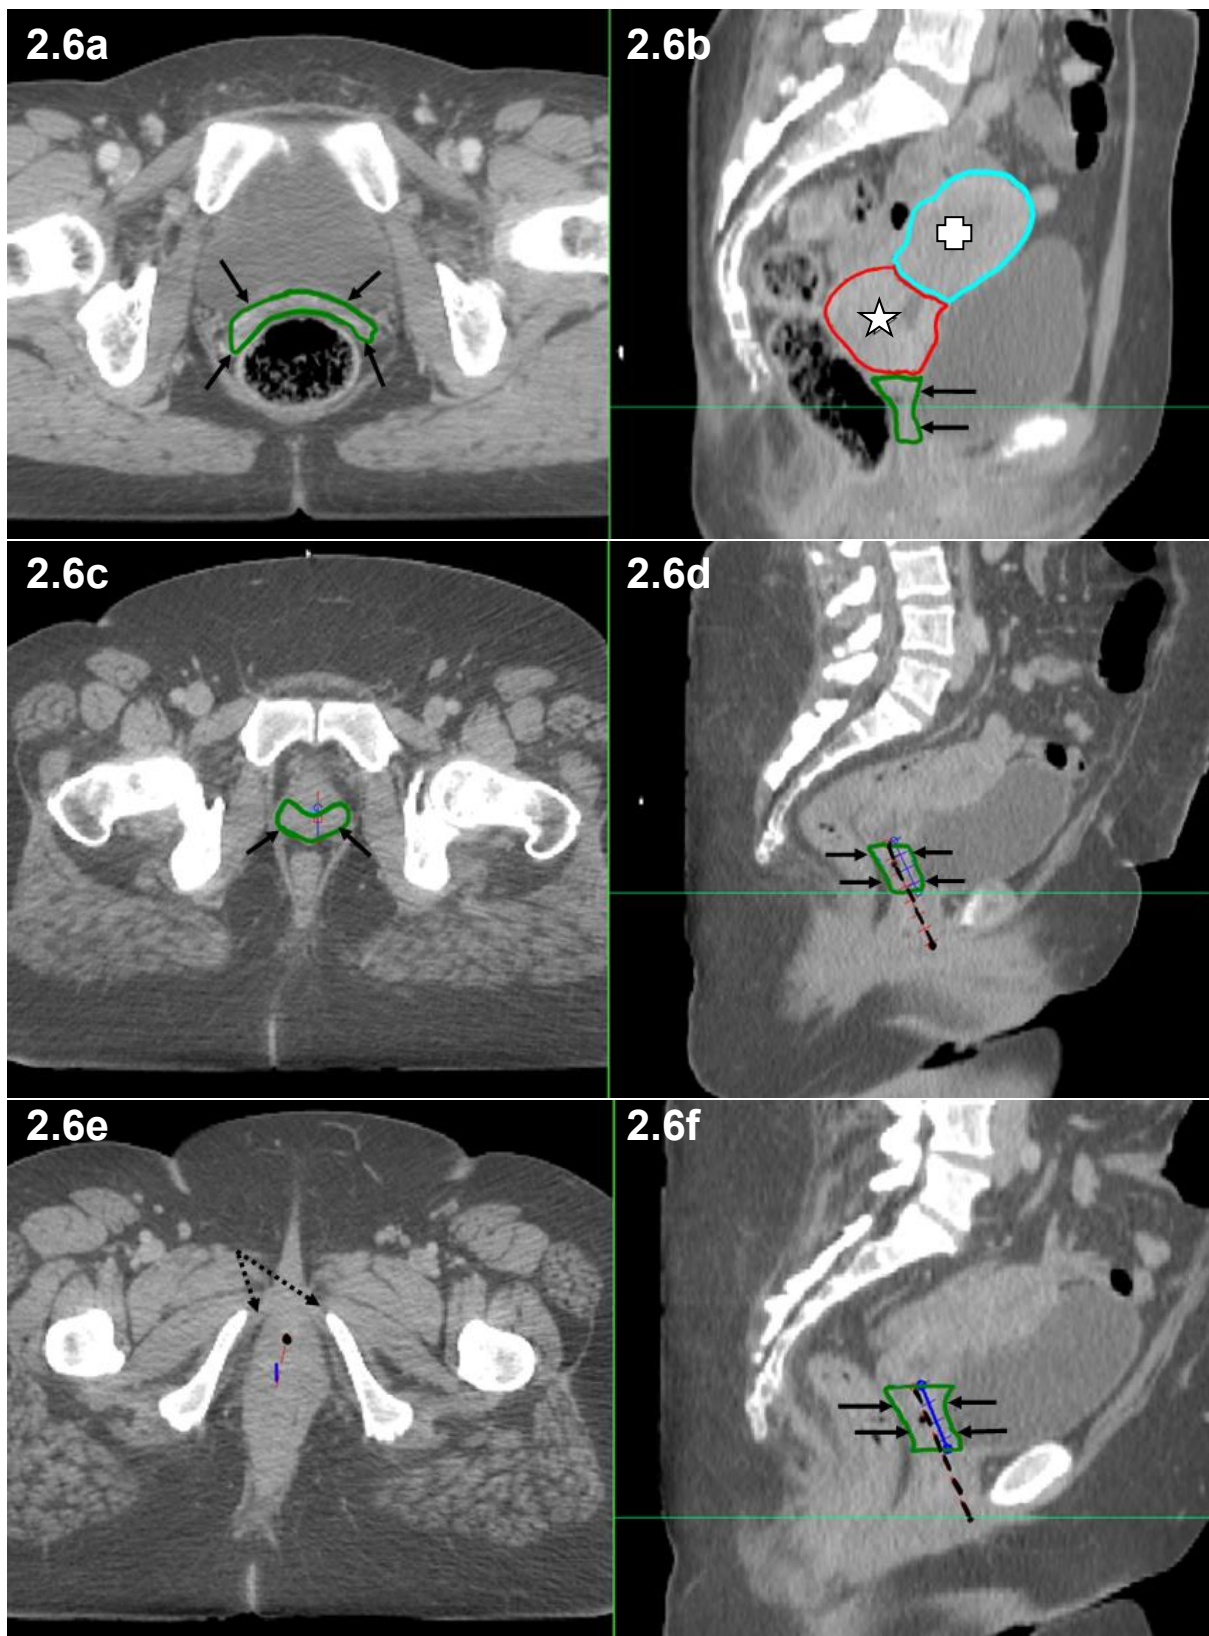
Transverse (a, c, e) and sagittal (b, d, f) CT demonstrating outlining of the upper half of the vagina (arrowed in a-d and f); dashed line on d and f follows the full length of the vagina; arrow on e demonstrates the clitoral crura corresponding to the introitus. The uterus (cross) and cervix (star) are also outlined on the sagittal view (b).
